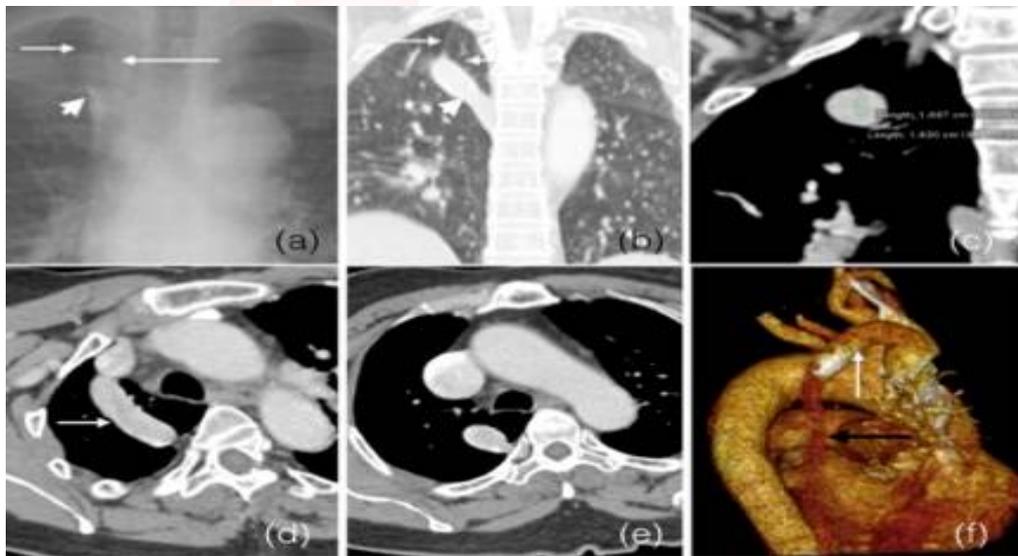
Chest radiograph (a) and coronal image MPR CT in lung window (b) showed azygos fissure (short arrow), azygos vein (arrowhead) and azygos lobe (long arrow). (c) Coronal CT thorax image to show the measurement taken at the arch of the azygos vein was 1.6cm x 1.9cm. (d) Axial CT images of the course of the azygos vein at the arch (arrow) and at the proximal end (e). Volume rendering image (f) in lateral projection showed azygos vein along the paravertebral region (black arrow) and at the arch (white arrow).
